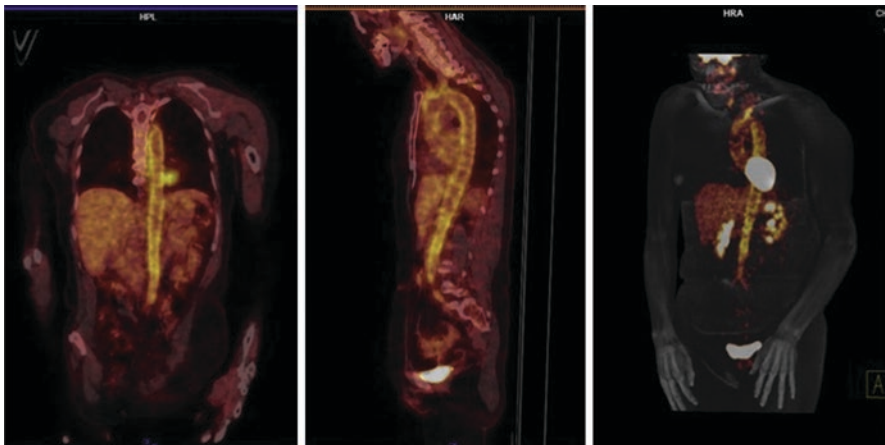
^{18}F -FDG positron emission tomography (PET) scan of a woman with giant cell arteritis. The PET scan reveals aortitis affecting the whole aorta. Reprinted, with permission, from Bossone E, et al. Aortitis. *Vascul Pharmacol.* 2016;80:1–10 [24].
